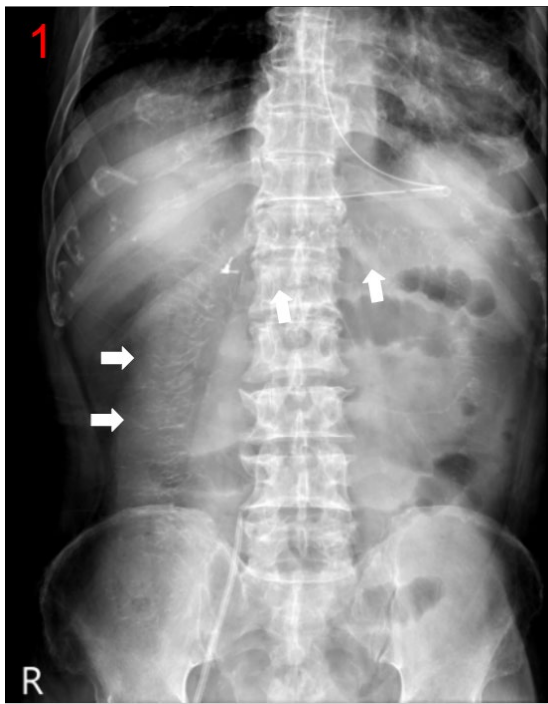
plain abdomen radiography showed treadlike calcifications.(white arrow)
